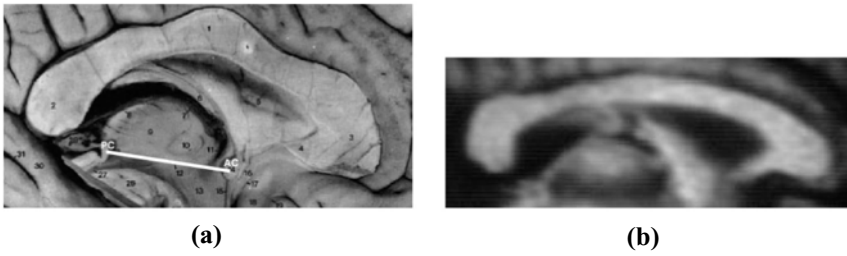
(a) The corpus callosum from an anatomical atlas and (b) the corresponding region of interest in a midsagittal MR image. On the left image the connecting line between the anterior commissure (AC) and the posterior commissure (PC), which is used for normalization, is also shown.
